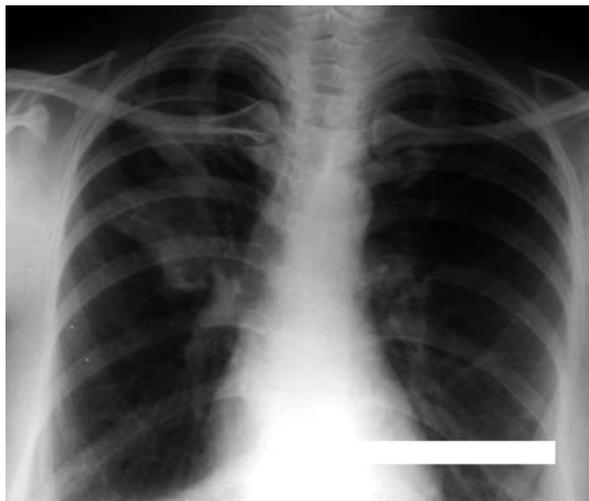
Chest radiograph showing finger-in-glove opacities in right mid zone
